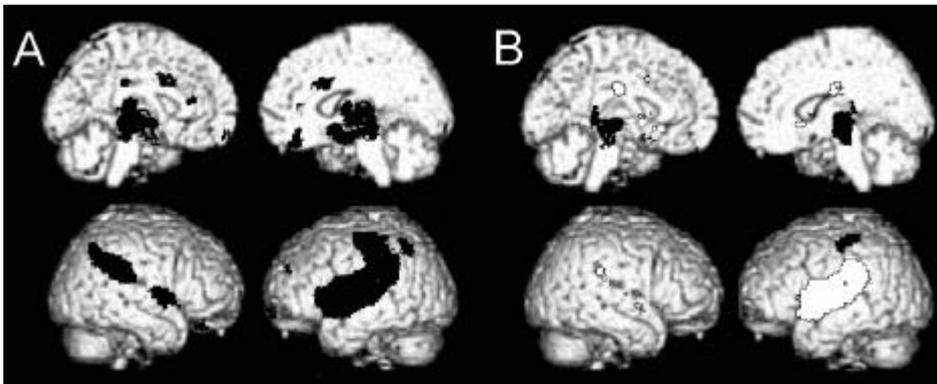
(A) Brain regions, shown in black, that activated during noxious stimulation in controls [subtraction stimulation-rest] projected on a 3-D spatially normalized brain MRI. (B) Brain regions that activated during stimulation in PVS patients, shown in black [subtraction stimulation-rest] and regions that activated less in patients than in controls [interaction (stimulation versus rest) x (patient versus control)], shown in white. (Adapted from ref.⁸)
